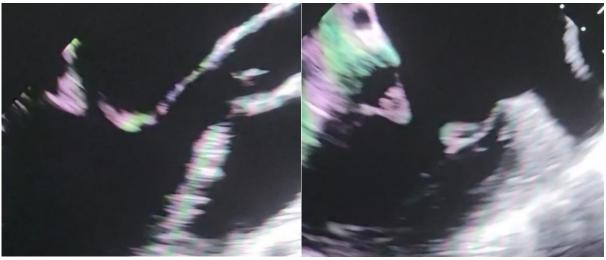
Transesophageal echocardiography (TEE) examination
